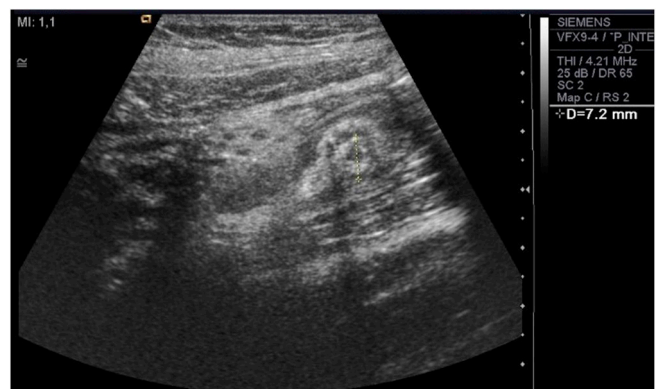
Transverse (short axis) ultrasound scan showing stump appendicitis with 7,2 mm in diameter.
